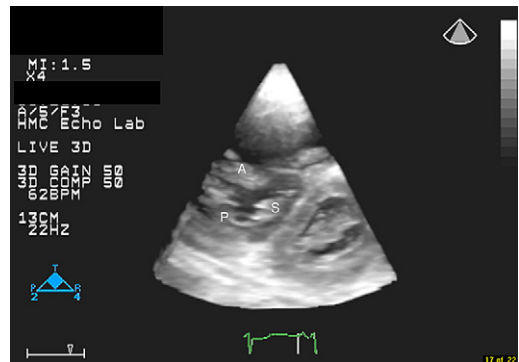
Parasternal short axis view with the right ventricle cropped in order to view the tricuspid valve from the right ventricle side. Right ventricular volume overload is noted with compression of the interventricular septum in diastole (case 4).
